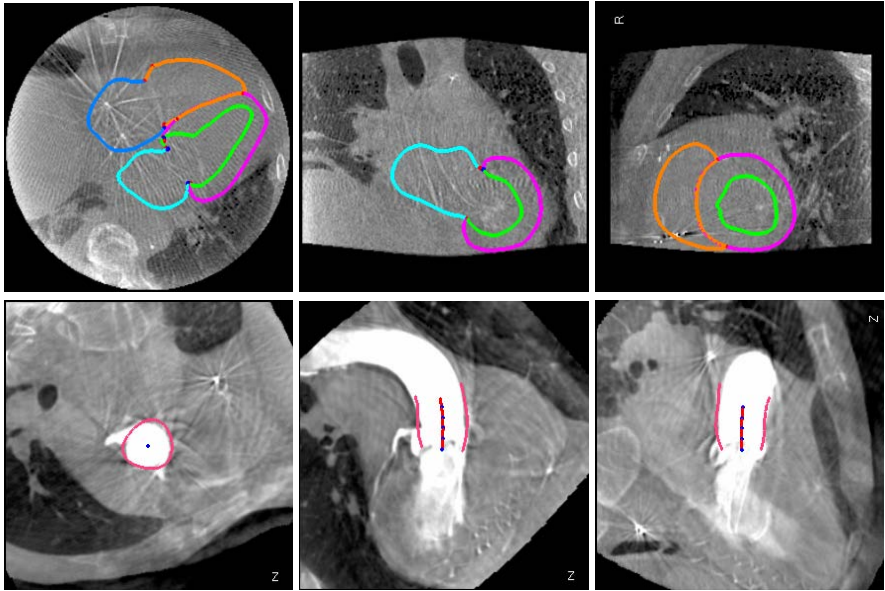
Warping of cardiac models extracted from CT to C-arm CT using segmented pericardium from both imaging modalities. Top row shows the warped four-chamber heart model on non-contrasted C-arm CT and the bottom row shows the warped aortic root model on contrasted C-arm CT. From left to right three orthogonal cuts of the volume are shown.
